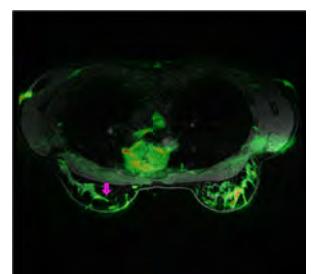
Overlap between a DWI and an anatomical image (case 7)
